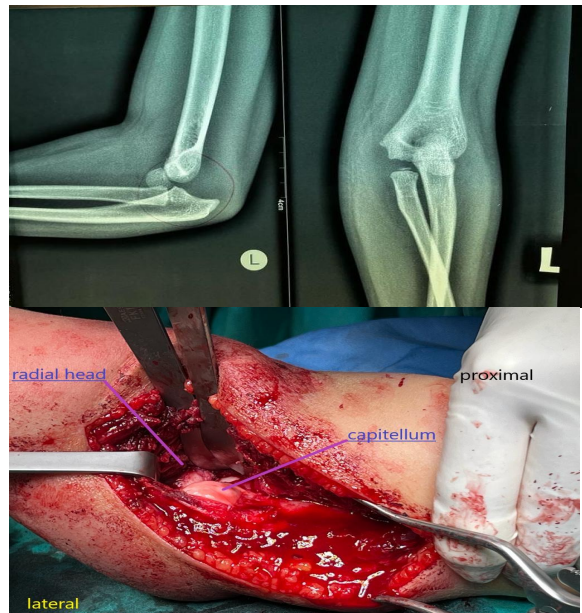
Trauma Radiographs
